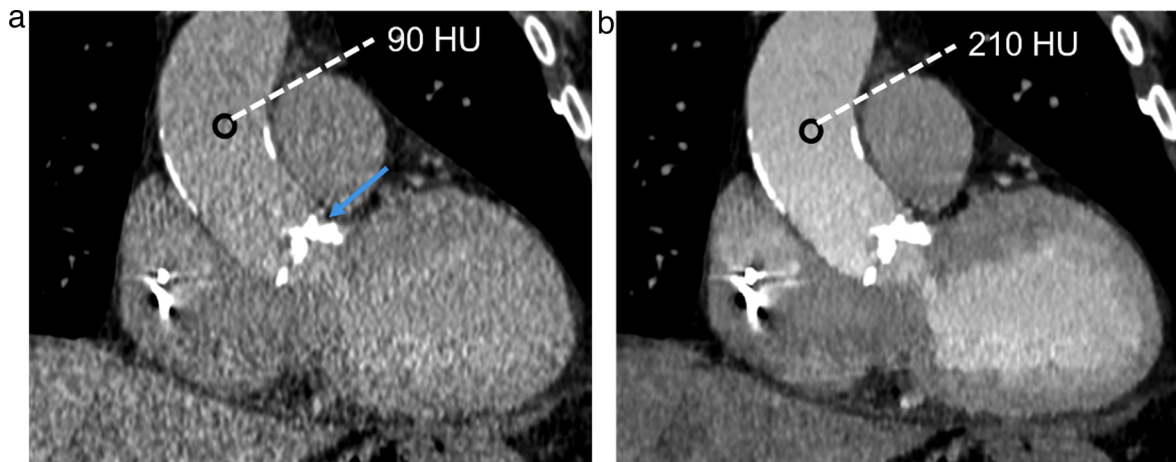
Contrast dose reduction with DECT. A 72-year-old male with history of renal dysfunction (eGFR =30 mL/min/1.73m²) comes for Pre – TAVI (Transcatheter Aortic valve Implantation) planning scan. (a) Conventional coronal CT image from DECT scan following intravenous administration of 25 mL of iodinated contrast shows poor contrast opacification of thoracic aorta. (b) Low keV VM image provides necessary contrast boost making the examination diagnostic at a very low contrast dose (as compared to 70-90 ml with conventional CT). Of note dense aortic valve calcification correlate with patient's severe aortic stenosis (Arrow in a).
